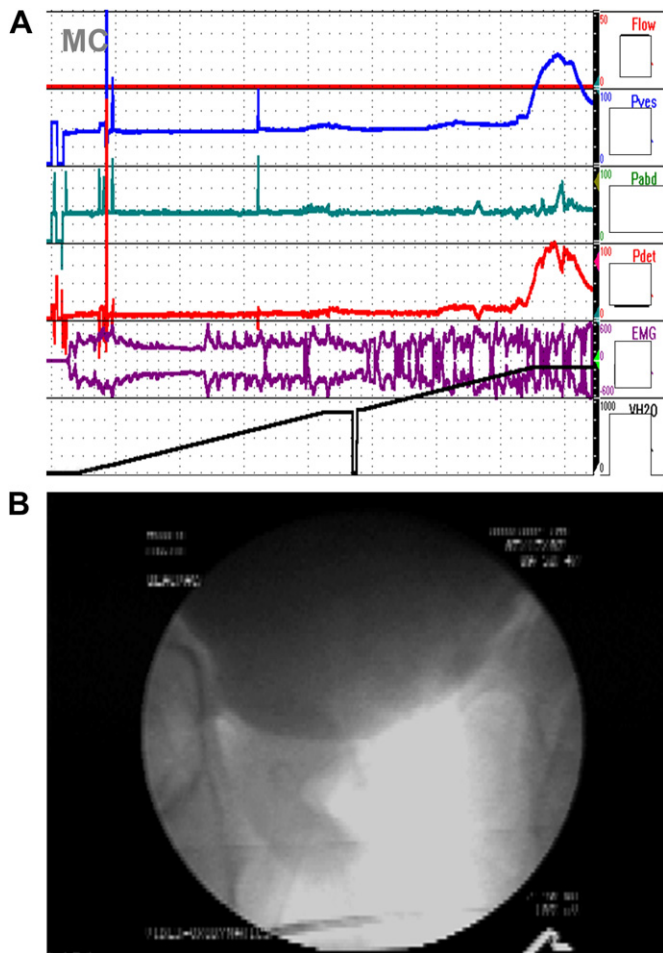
Large capacity bladder and bladder neck obstruction. A 31-year-old man had been treated with intermittent catheterization for 2 years because of urinary retention that was thought to be due to a neurogenic bladder. His initial urodynamic study was thought to demonstrate detrusor areflexia because there was no bladder contraction up to a volume of 1200 mL at which time the examination was discontinued. A. Urodynamic study. During this study, the bladder was filled until he felt comfortably full (1450 mL) and when asked to void, he had a sustained detrusor contraction to 105 cmH₂O, but he was still unable to void. B. X-ray exposed during the detrusor contraction showing complete obstruction at the bladder neck. He underwent transurethral resection of the prostate and voided normally thereafter, but his creatinine remained unchanged.
